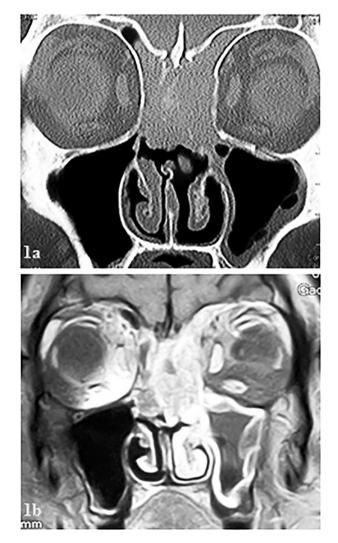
Preoperative coronal CT scan (a) and a coronal T1 MRI post-contrast (b) showing a recurrent inverted papilloma which is occupying both nasal cavities, olfactory recesses, ethmoidal air cells, both frontal sinuses and invading the nasal septum.
